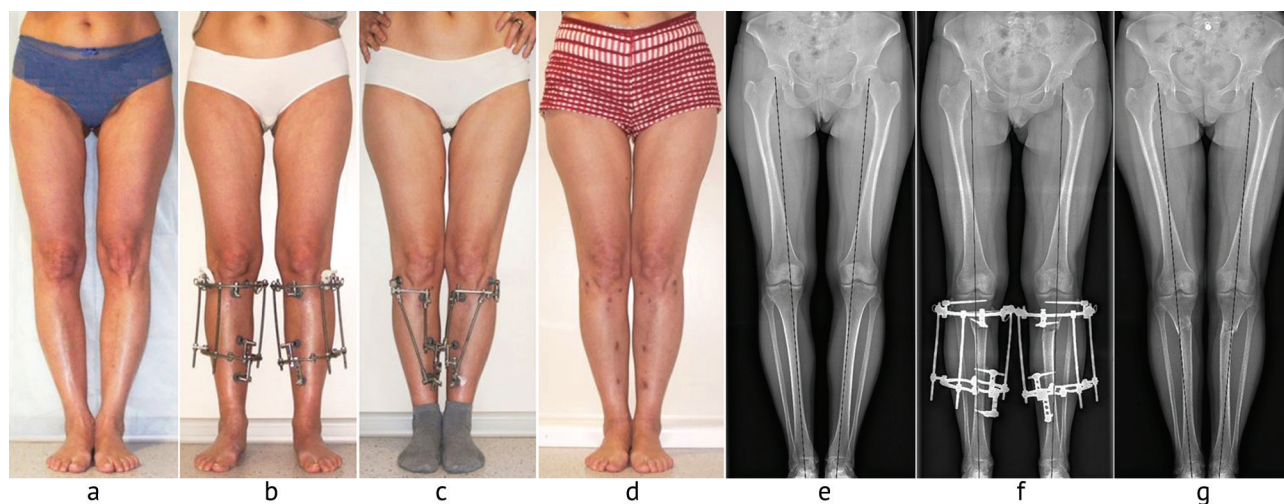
A 50-year-old female patient with varus deformity of the lower limbs: *a* appearance before surgery; *b* during the correction with the Ilizarov apparatus; *c* photo 2 months after surgery with monolateral fixators on to approximate the feet to each other; *d* six months after the operation; *e* radiographs before the operation; *f* radiographs taken in the course of correction; *g* radiographs taken six months after the operation
